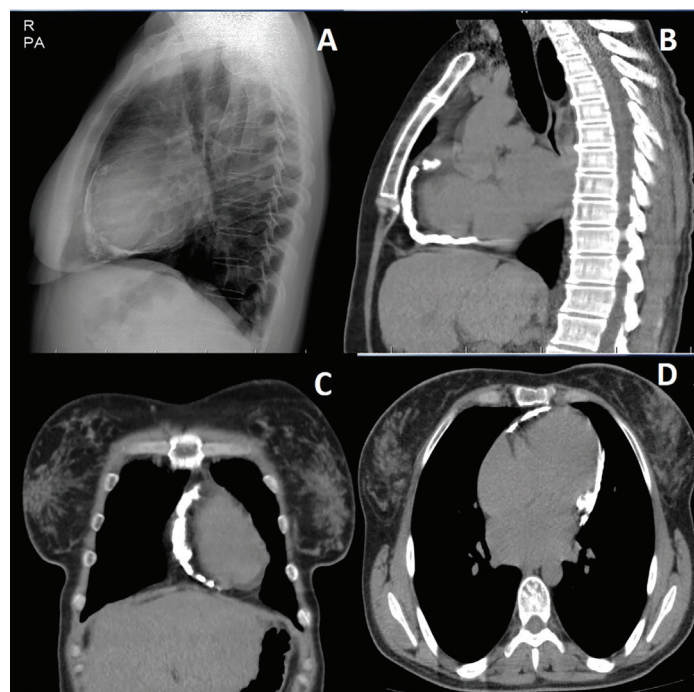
(A) Lateral chest X-ray shows egg-shell pericardial calcification around the heart. (B-D) Transverse computed tomography with sagittal and coronal reconstructions shows diffuse pericardial calcified thickening
